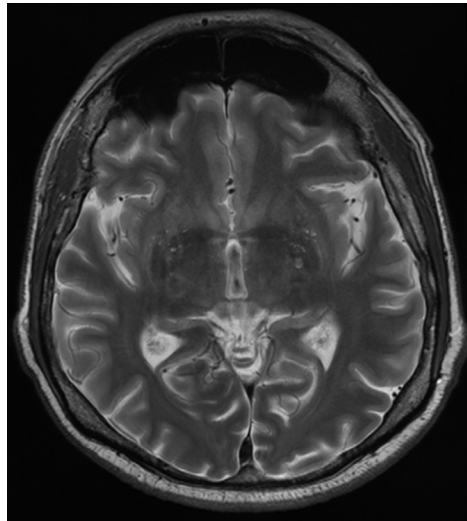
T2-weighted axial magnetic resonance image showing lacunar infarcts in the nuclei of the base and in the semi-oval centers on both sides.
